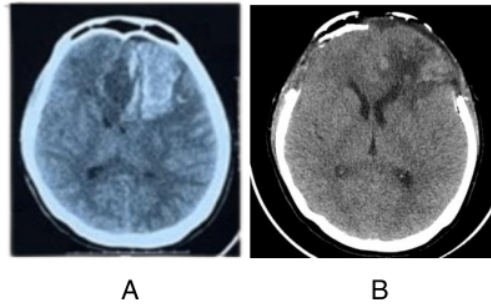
(A) Non-contrast CT Brain at admission; (B) Non-contrast CT Brain after craniotomy
